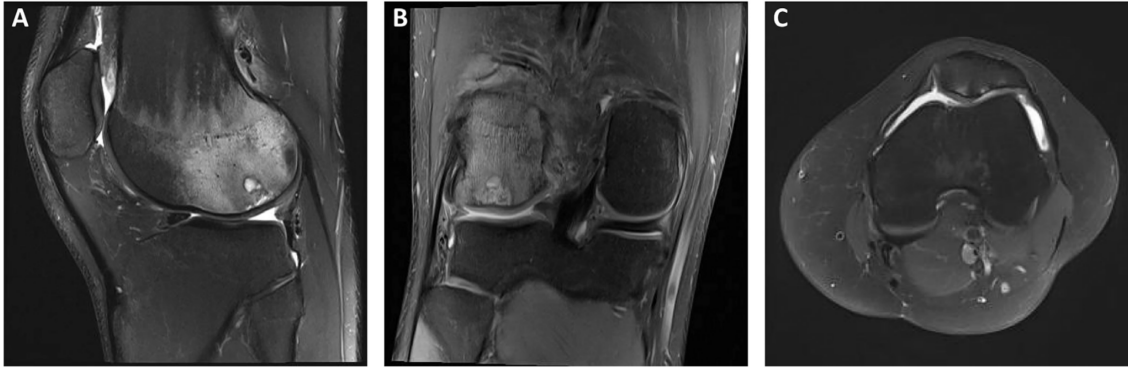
Right knee preoperative magnetic resonance imaging. T2 weighted sagittal (A) and coronal (B) MRI pictures showing subchondral edema and a localized chondral defect in the posterior lateral femoral condyle. (C) A focal chondral defect of the medial patellar facet may be seen in the T2 weighted axial MRI picture (11)
